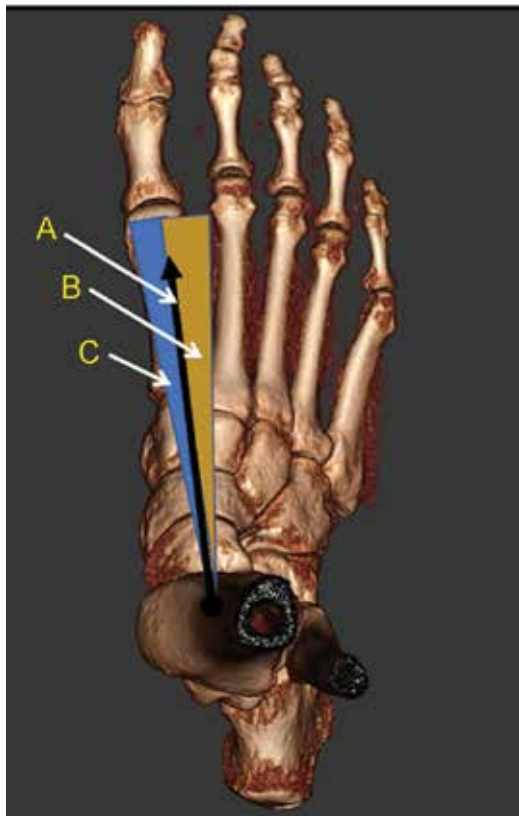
Dorsoplantar weightbearing three-dimensional CT. TTJ is in neutral position. "A" is the bisection of the talus. "B" indicates TTJ supination. "C" indicates TTJ pronation.
